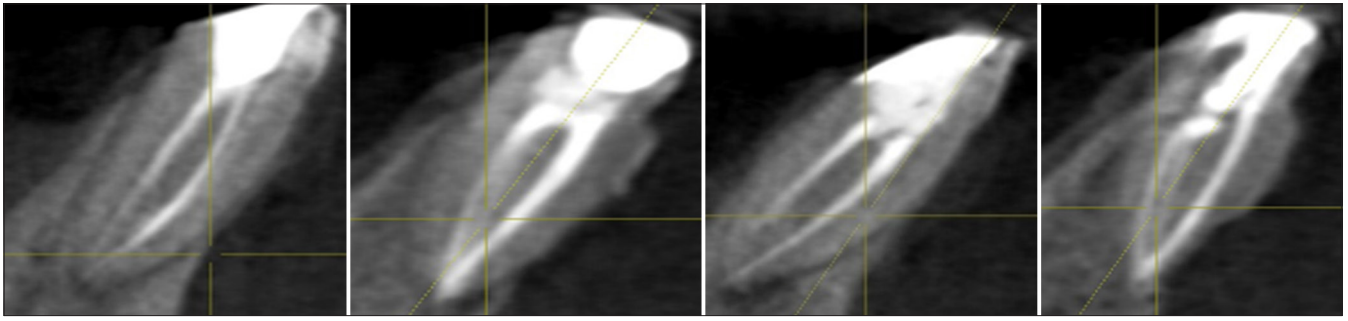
Cone beam computed tomography showing double canal in each of the mandibular incisor.
